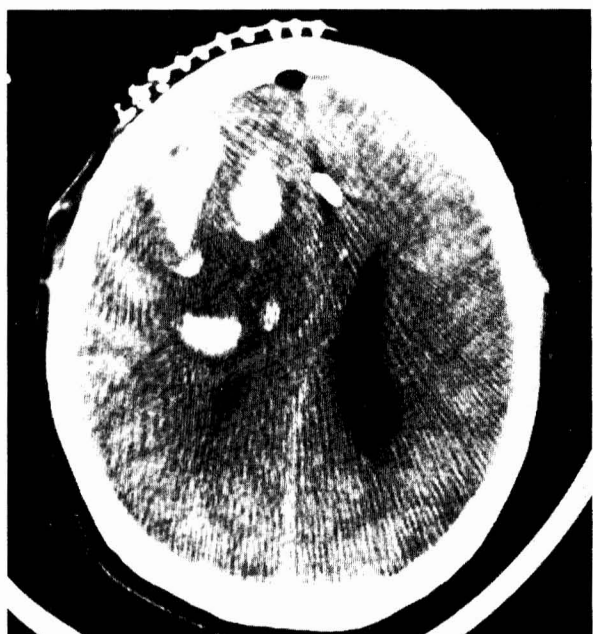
CT scan 36 hours after surgery shows a hemorrhagic infarct involving the right frontal and parietal lobes.
